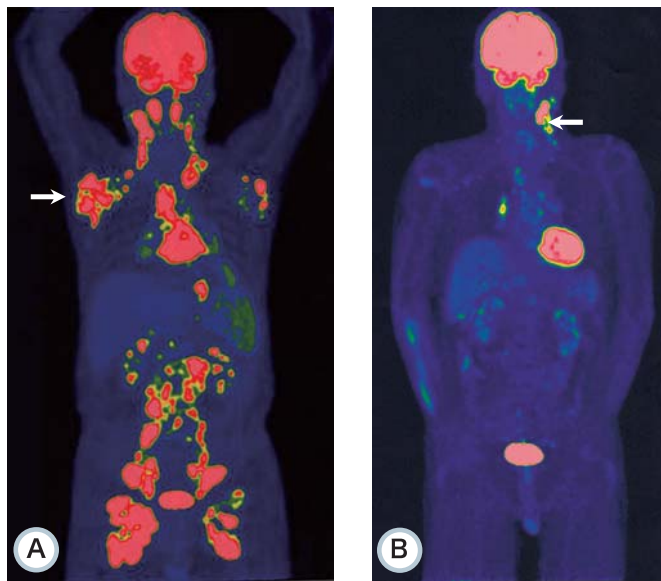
Imaging findings. (1A) At the time of initial diagnosis, ¹⁸F-fluorodeoxyglucose-positron emission tomography/computed tomography (FDG-PET-CT) showed FDG accumulation in lymph nodes from the neck to the popliteal fossa, in the pharynx, and in the spleen. Evidence of pericardial effusion, pleural effusion and ascites was also observed. SUVmax in the right axillary lymph node was 9.0 (indicated by the *white arrow*), which was, therefore, selected as the site of biopsy. (1B) At the time of relapse, PET-CT showed FDG accumulation in the left nasopharynx, and in the left neck and mediastinal lymph nodes. SUVmax in the left neck lymph node was 12.3 (indicated by the *white arrow*); this node was therefore selected as the biopsy site.
